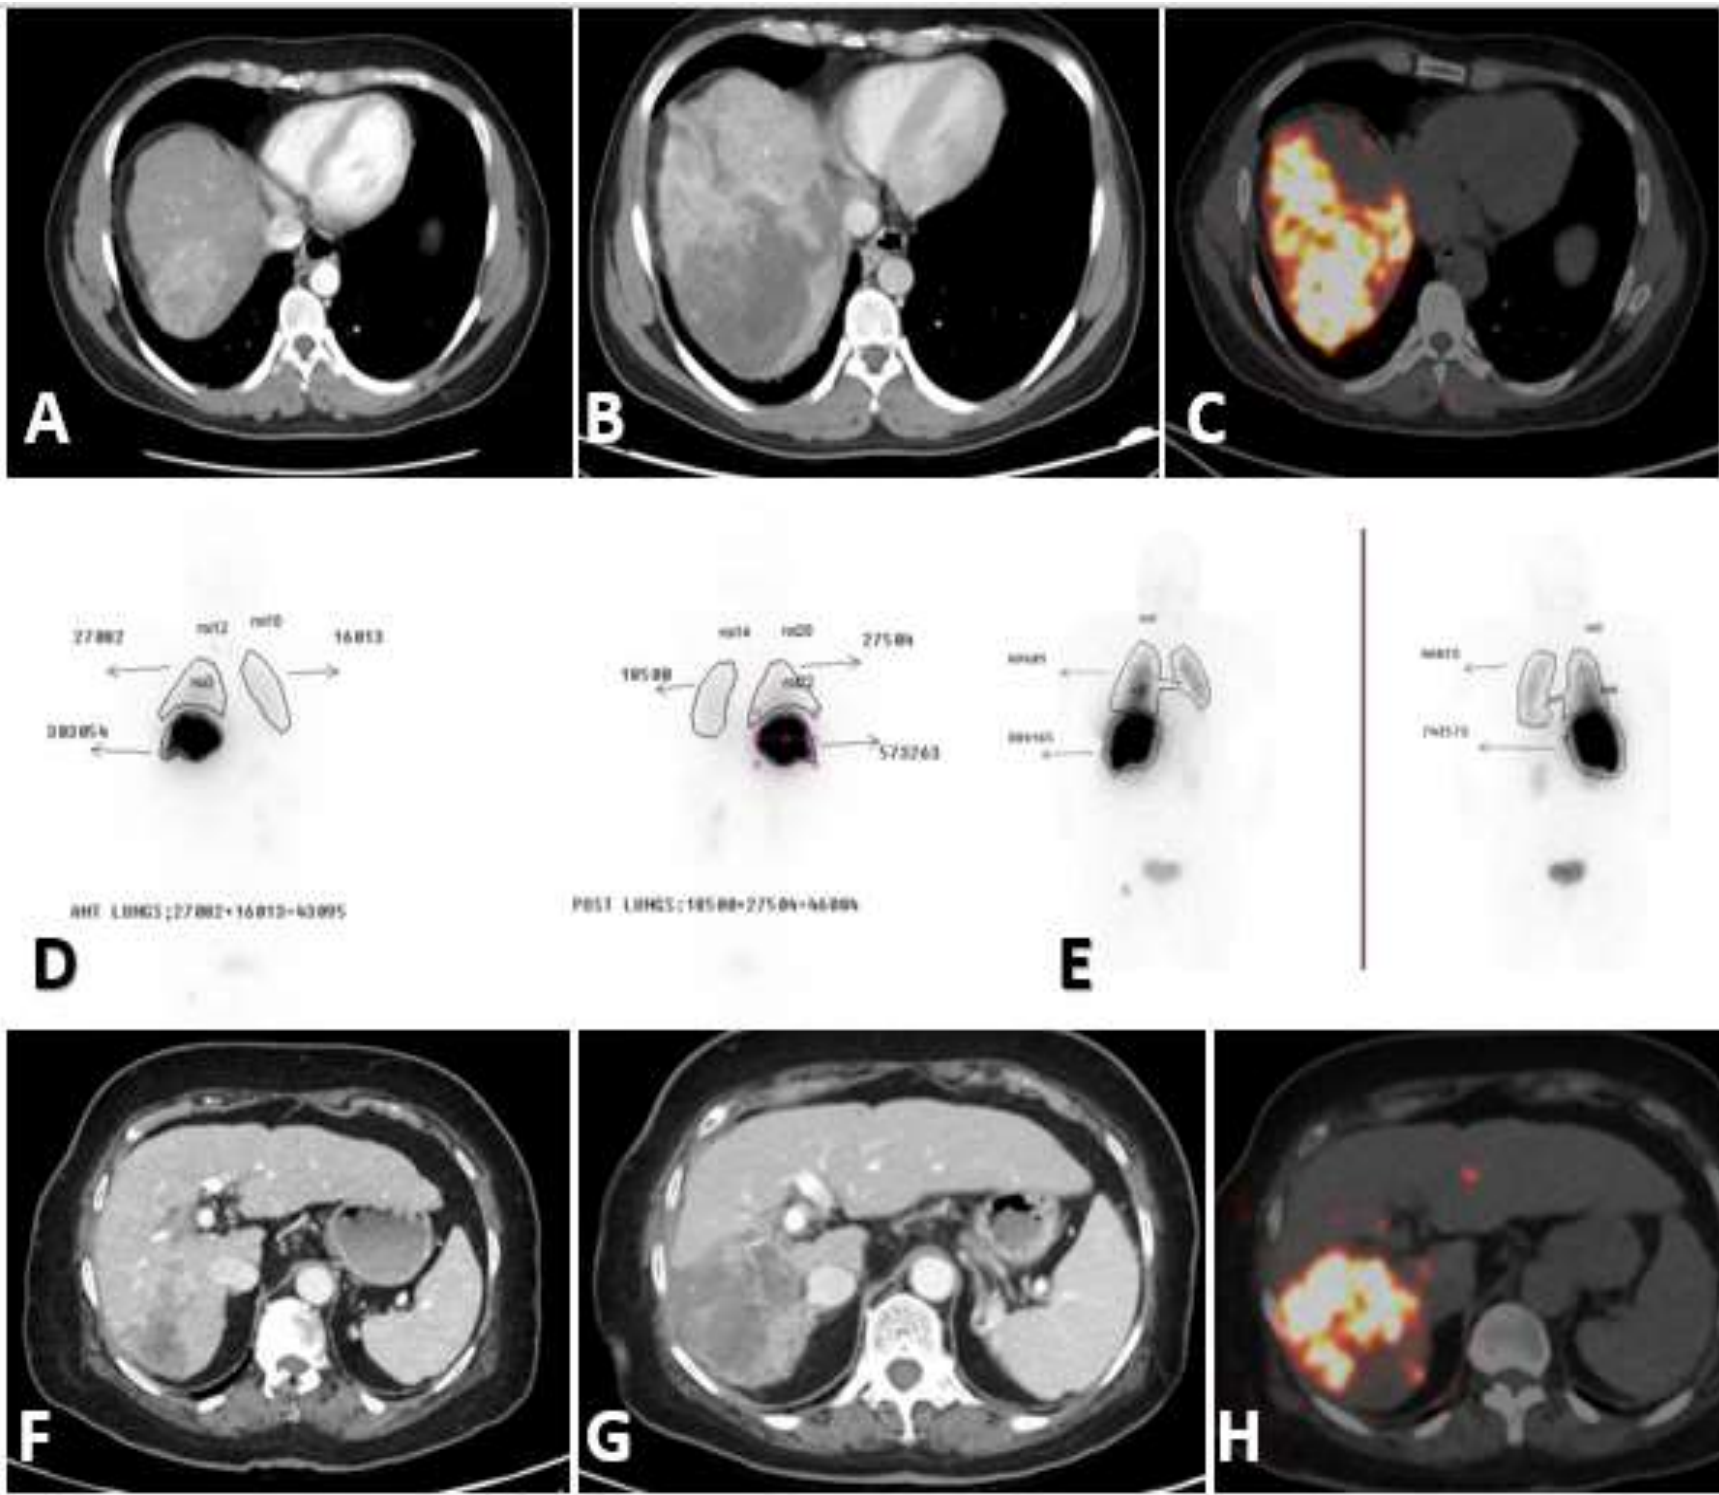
A & F are the pretherapy and Fig. B & G are the post therapy follow up CT scans of two different patients. Fig. C & H are the axial image of post therapy PET CT images acquired 24 hours after therapy. Fig. D & E are the pre therapy 99mTc MAA images of the two patients and calculated shunts were within normal limits for Y-90 therapy.
